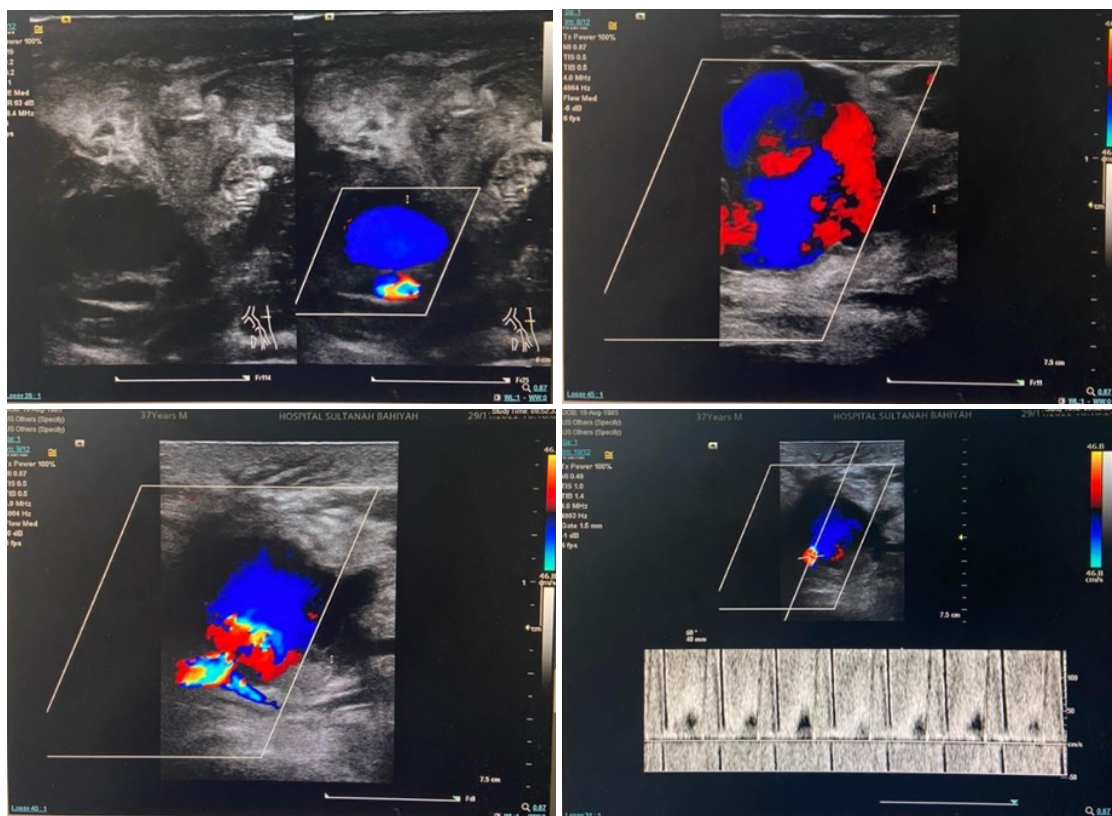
Ultrasonography: “yin-yang” sign indicating bidirectional flow due to swirling of blood within the pseudoaneurysm as the portion that is moving toward the transducer is red and the portion that is moving away from the transducer is blue [5]. Note the surrounding subcutaneous oedema.
